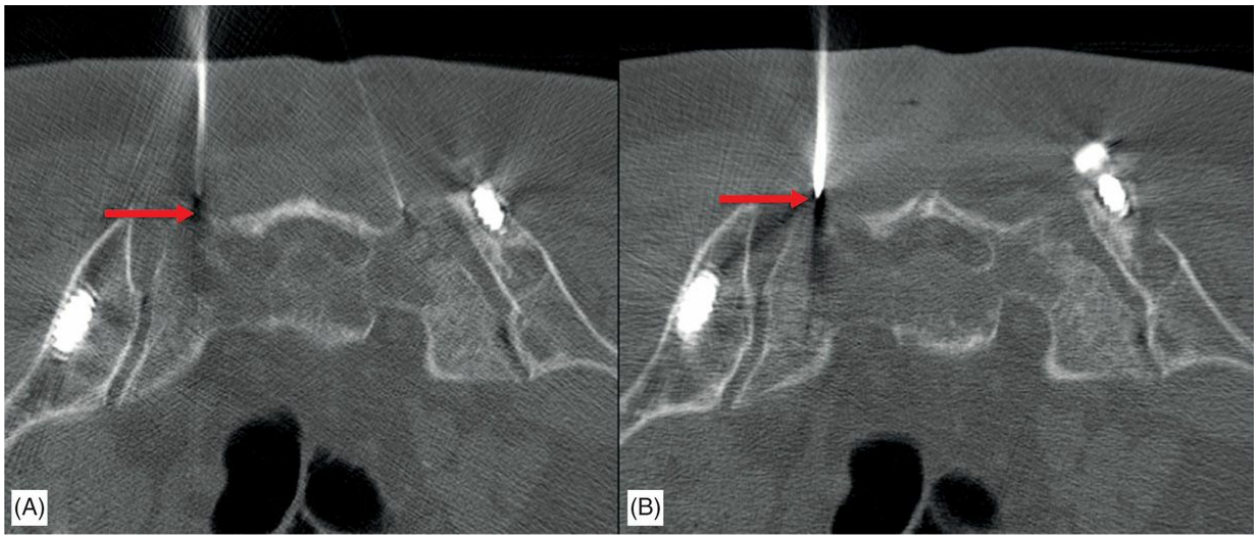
Demonstration of needle tip during sacroplasty. (A) Axial CT during localization reveals minor shadowing artifact arising from near the tip, however less than expected for a 13-gauge needle. (B) Imaging 2.5 mm cranial identifies further shadowing artifact as well as the diamond tip bevel confirming exact needle tip position.
